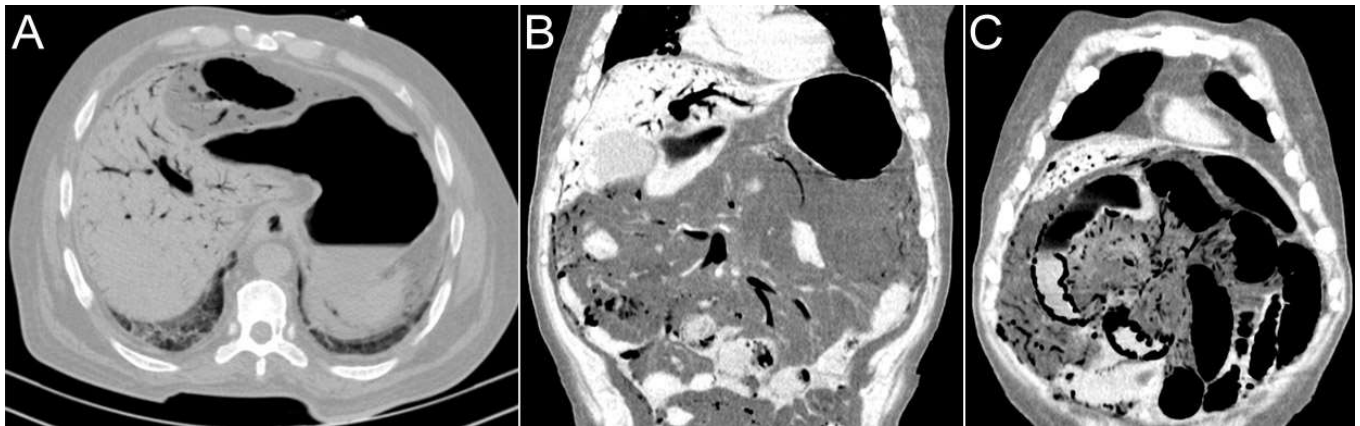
A,B. Gas in the HPVS in an axial and coronal CT scan. C. Intestinal pneumatosis in the coronal CT scan
